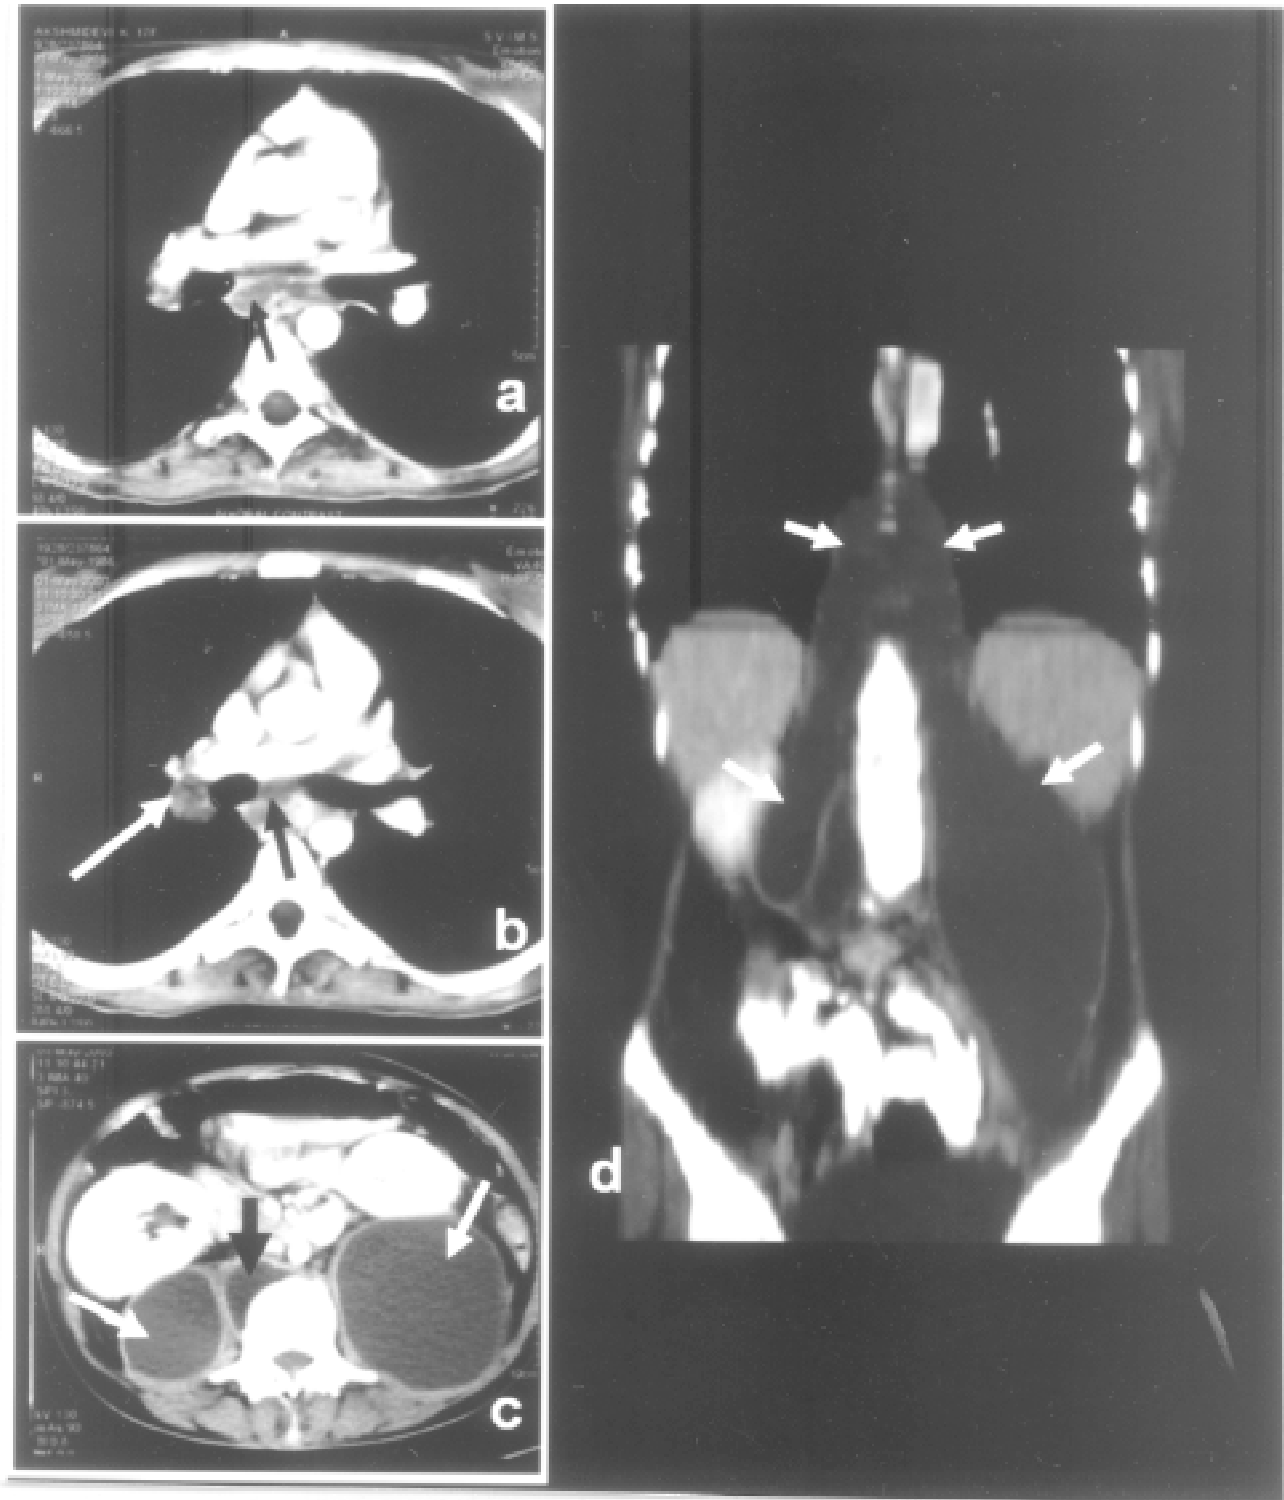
Contrast enhanced computerized tomographic (CECT) scan of the chest of a young woman who presented with low grade fever for 3 months, cough and dysphagia showing subcarinal (a) and right hilar (b) lymph nodes. Arrows points to hypodensity which indicates necrosis in the lymph node. CECT scan of the abdomen of the same patient showing bilateral psoas abscesses (c) (arrows). Coronal reconstruction of the CECT scan of the abdomen of the same patient showing bilateral psoas abscesses (d) (arrows). CT guided fine needle aspirate from the psoas abscess revealed numerous acid-fast bacilli.
